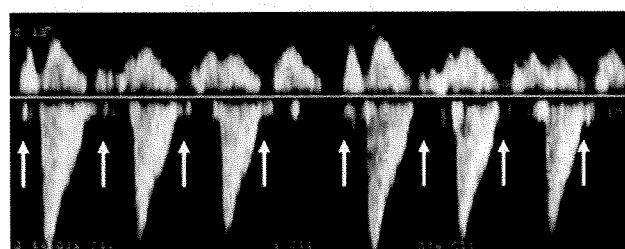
Wenckebach type atrioventricular block. Simultaneous Doppler trace of the ascending aorta and the superior vena cava reveals atrial contraction with regular rhythm (arrows), atrioventricular conducting time of gradual prolongation, and block with pose of ventricular contraction.
